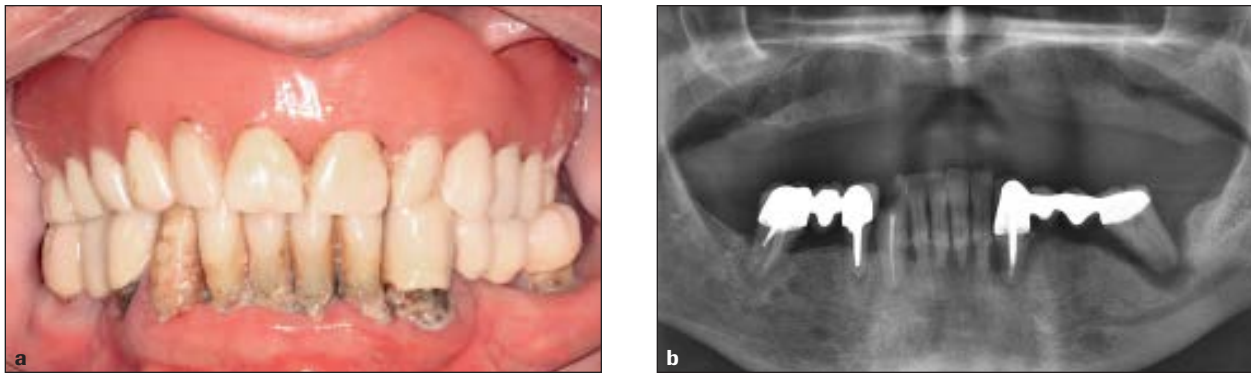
(a) Initial clinical situation and (b) preoperative panoramic radiography.
